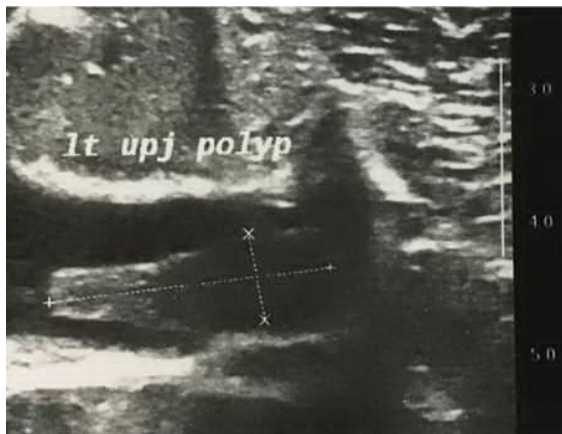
Sonographic image demonstrating the fibroepithelial polyp.
